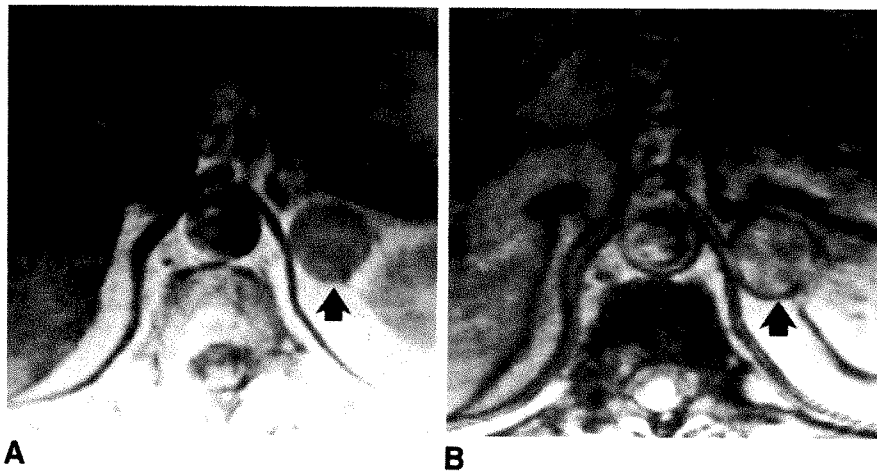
A and B, Standard spin-echo (A) and modified Dixon sequence (B) MR images (2000/20) in a patient with a 25-mm-diameter left adrenal adenoma (arrow). Lipid content of tumor measured by using these two images was 14%.
